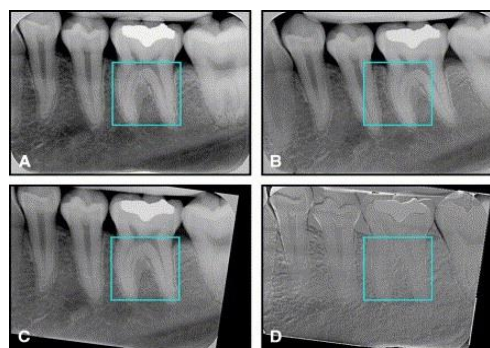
Digital subtraction radiography
